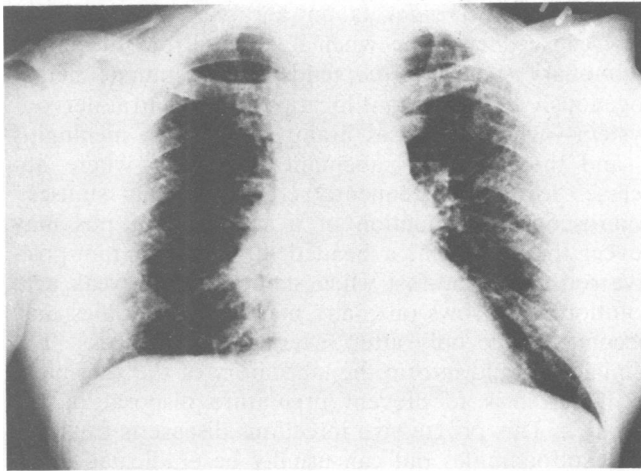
Chest roentgenogram showing diffuse interstitial infiltrates.
